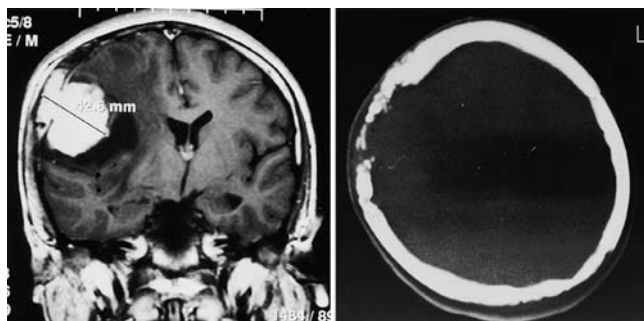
Left*: Contrast-enhanced coronal T₁-weighted MR image revealing a homogeneously enhancing, solid mass lesion with a cystic component in the right frontoparietal region. Marked edema and a midline shift are evident. The mass is protruding through the expanded diploë in the calvaria. *Right*: Preoperative computerized tomography scan demonstrating the bone destruction caused by the mass, which is indicated by the erosion of the tabula interna.
